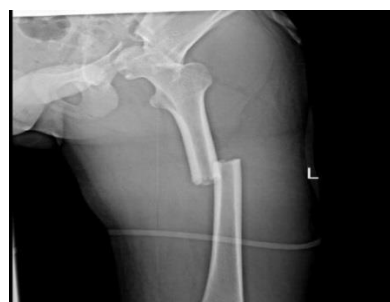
Preoperative anteroposterior (AP) radiograph of the femur
